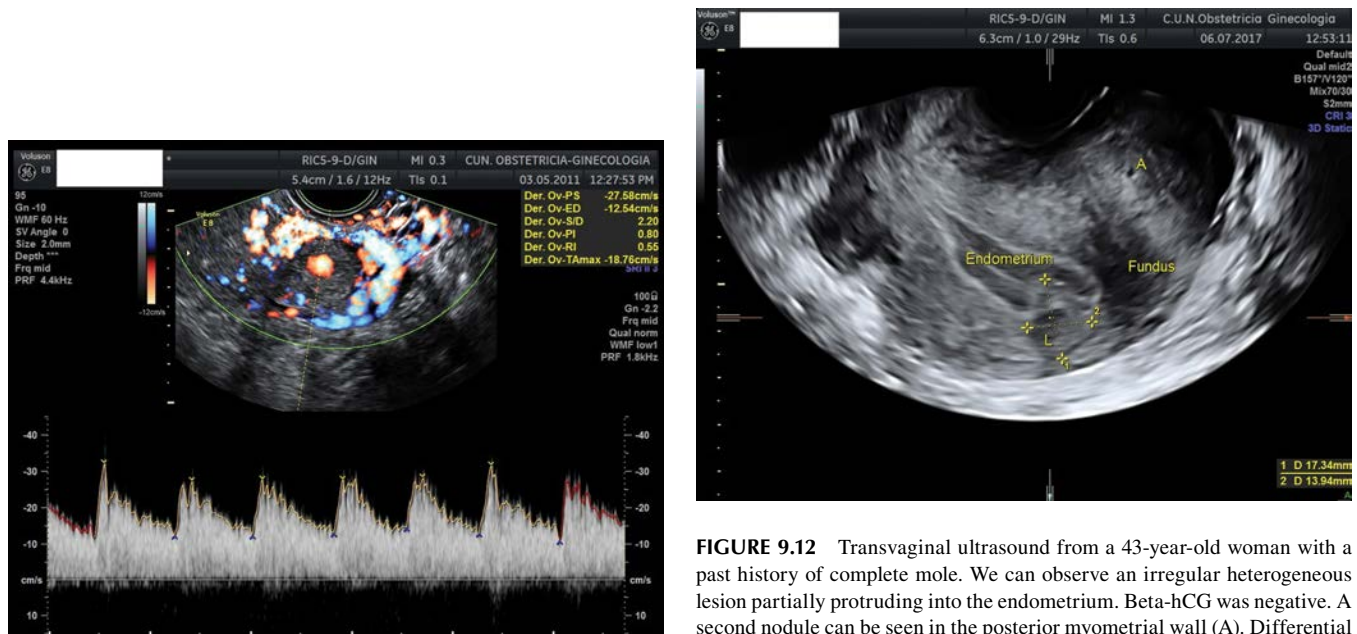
Transvaginal color ultrasound showing the characteristic blood flow (high velocity/low resistance) in gestational trophoblastic disease.
